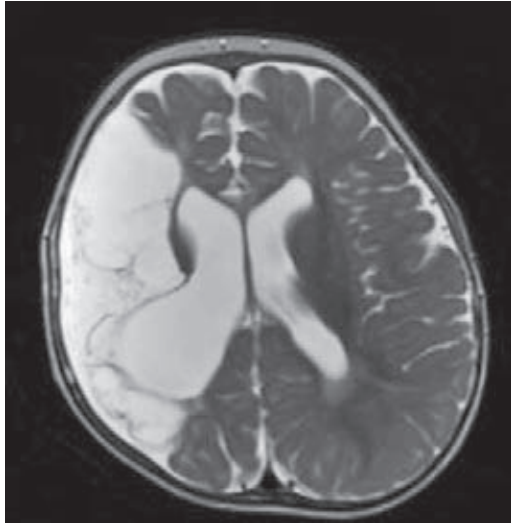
Established right middle cerebral artery (MCA) territory infarct. Axial T2-weighted MR image shows cystic change (encephalomalacia) in the right MCA territory, due to loss of brain tissue. The right lateral ventricle is enlarged due to the adjacent brain loss
